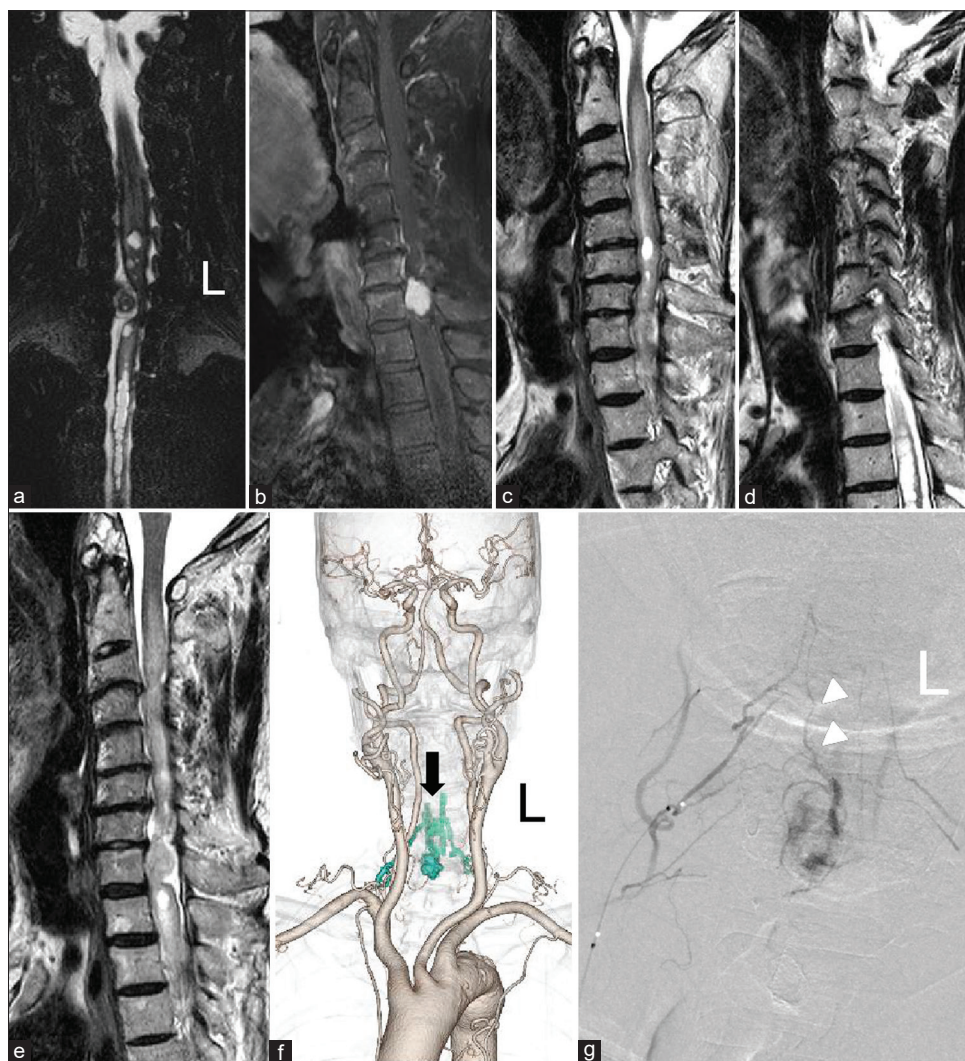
Preoperative imaging (L: Left). (a) T2-weighted MRI; (b) Gadolinium-enhanced T1-weighted MRI) an intradural extramedullary tumor was suspected. The tumor was homogeneously enhanced. (c-e) Spinal edema and syringomyelia are observed on T2-weighted MRIs. (f) Three-dimensional reconstructed CTA showing that the lesion is fed by a right radicular artery of C5–C6 (black arrow). (g) A right vertebral angiogram showing that the right radicular artery of C5-6 is a feeder of the lesion (white arrow heads). MRI – Magnetic resonance imaging; CTA – Computed tomography angiography
